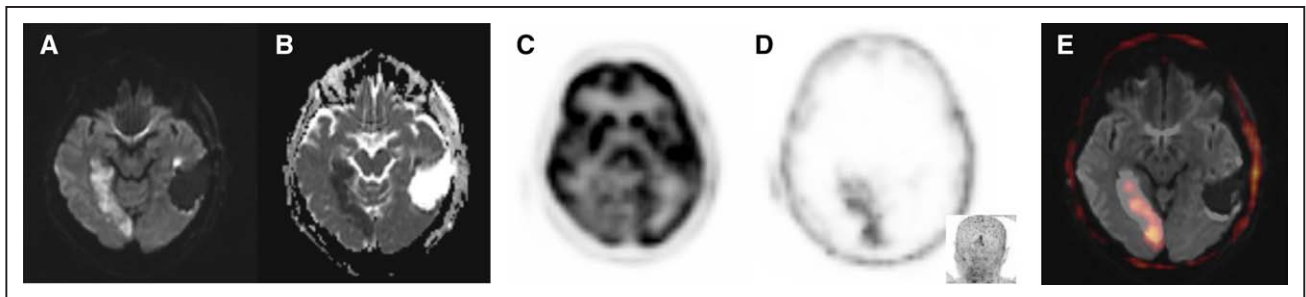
Cerebral magnetic resonance imaging (cMRI) at day 2 after brain surgery shows demarcation of right posterior ischemia with corresponding changes in diffusion-weighted images (A; b value = 1000 s/mm^2) and apparent diffusion coefficient values (B). [^{18}F]FDG-PET demonstrates significantly reduced tracer uptake in the infarction area (C). In contrast, [^{68}Ga]Pentixafor-PET (one day later) visualizes upregulation of CXCR4 (D, Inset; maximum intensity projection; standardized uptake value $_{\text{max}}$ = 4.08 versus standardized uptake value $_{\text{mediastinal bloodpool}}$ = 1.62), which correlates with cMRI changes (E, DWI/PET fusion). CXCR indicates CXC-motif chemokine receptor; DWI, diffusion-weighted image; and PET, positron emission tomography.
